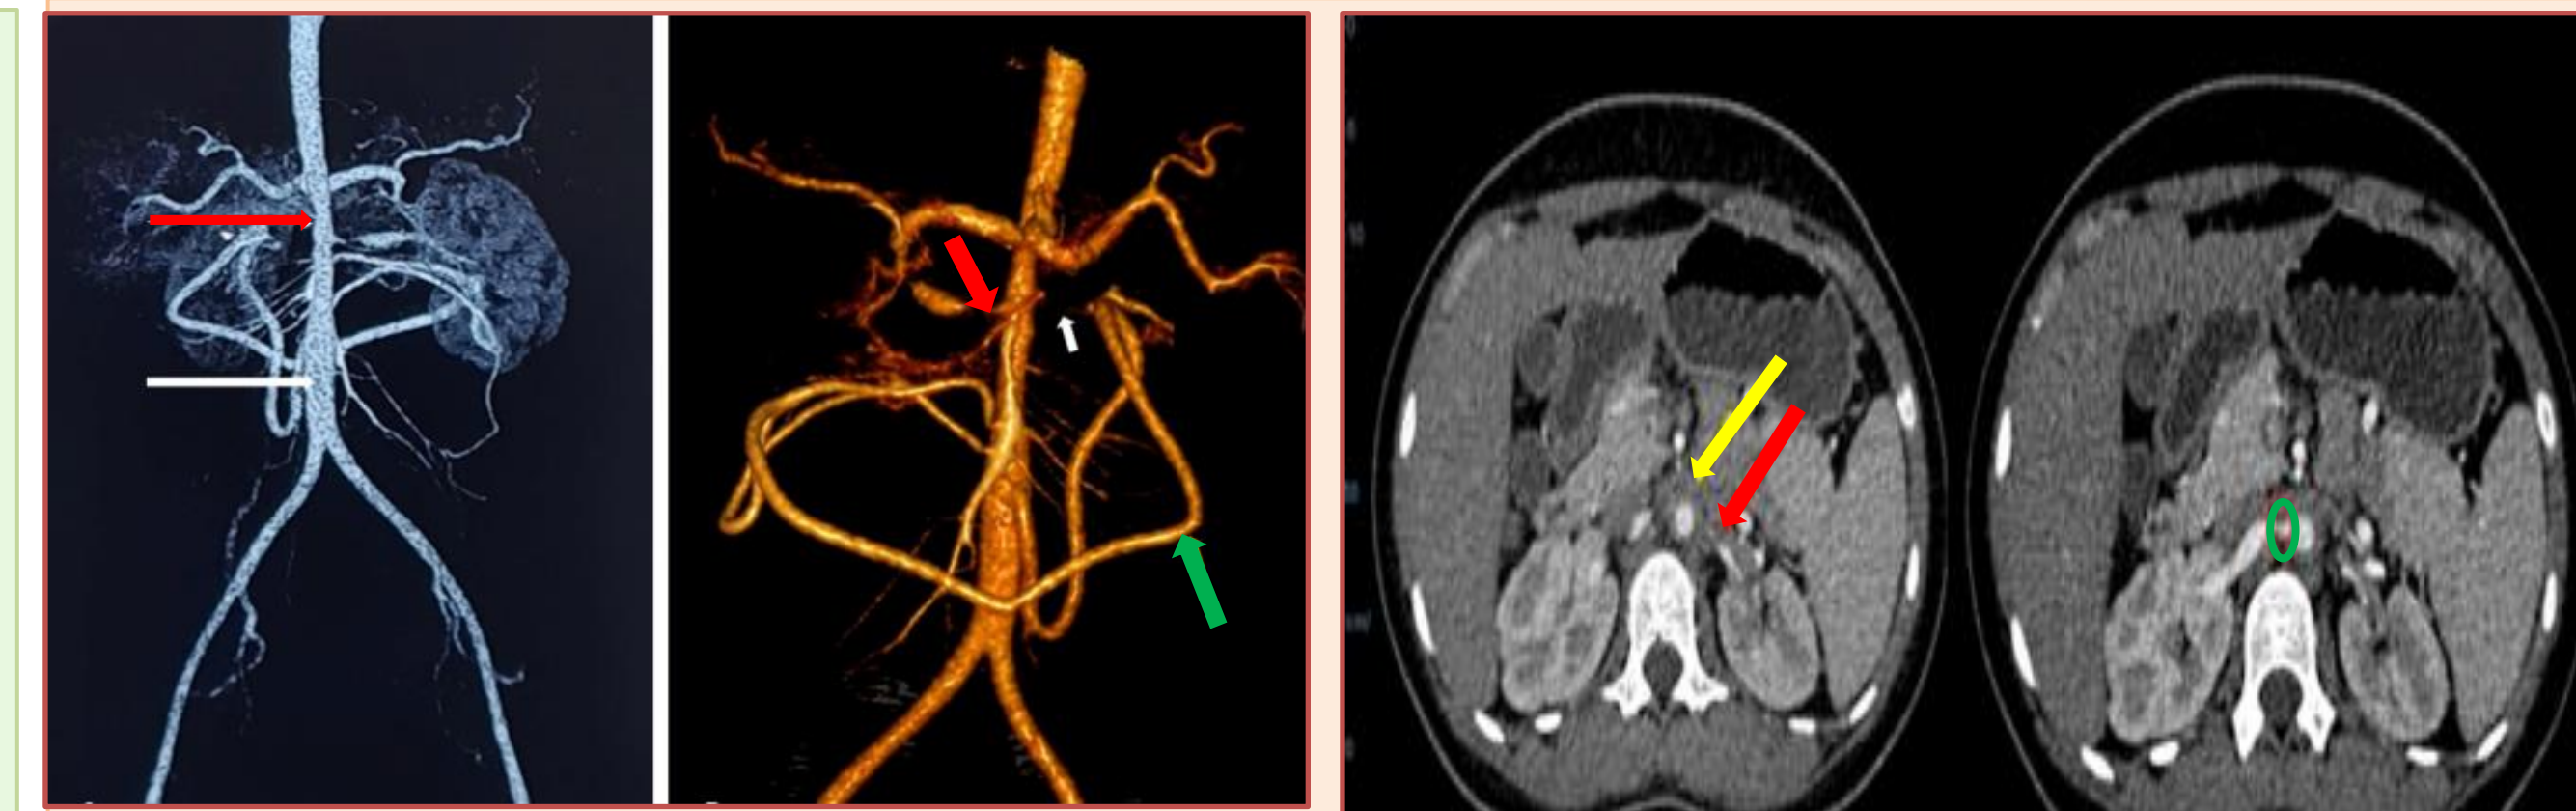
Contrast enhanced computed tomography (CECT) arterial phase image showing A: Significant luminal narrowing of distal descending thoracic aorta (red arrow) with post stenotic dilatation (white arrow) B: 3D Volume rendered image showing grossly stenosed right renal artery (red arrow) with post stenotic dilatation. The proximal left renal artery is not visualised (white arrow) due to severe narrowing. The inferior mesenteric artery is hypertrophied (green arrow) and anastomosing with branches of SMA.
